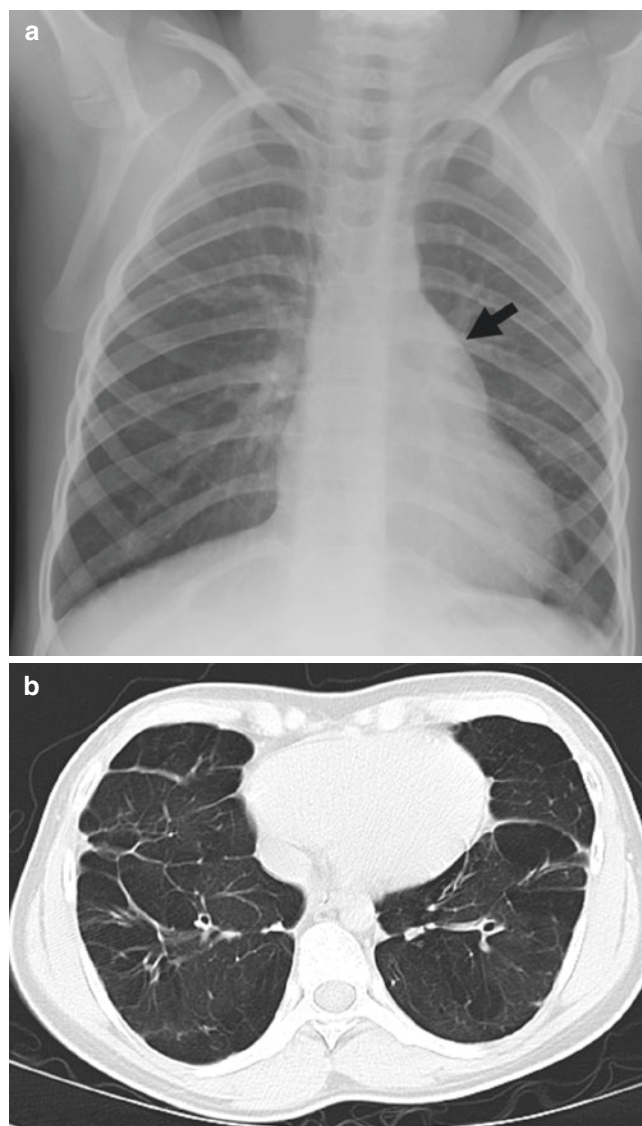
Eight-year-old boy with prior history of prematurity and bronchopulmonary dysplasia who presented with pulmonary hypertension. (a) Frontal chest radiograph shows an enlarged central pulmonary artery (arrow). Mild hyperlucency is also noted within the bilateral lower lobes. (b) Axial lung window CT image demonstrates marked lung parenchymal damage characterized by the areas of coarse parenchymal thickening and air-trapping
